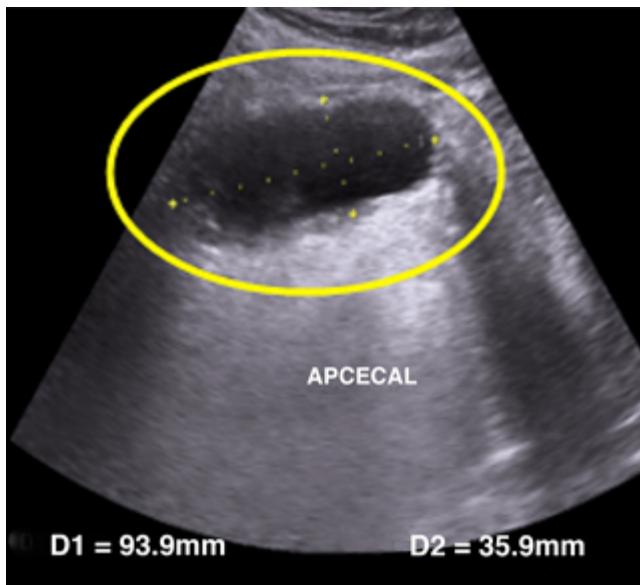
Abdominal ultrasound: dilatation of the cecal appendix (circle).
